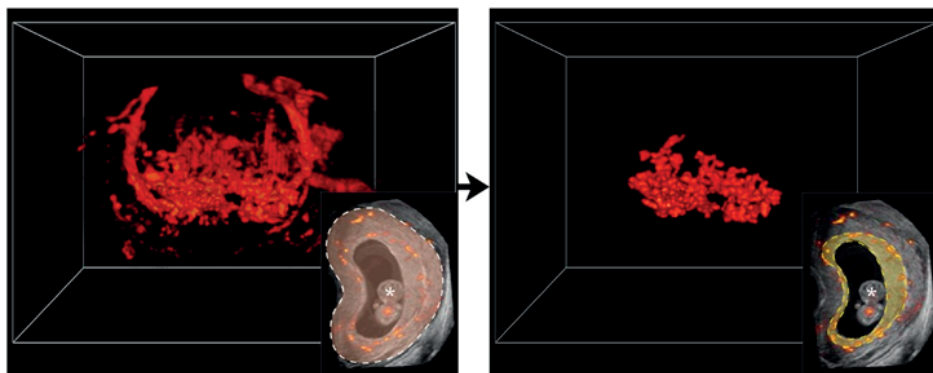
Visualization of a three-dimensional power Doppler utero-placental vascular volume in Virtual Reality. On the left; complete three-dimensional power Doppler vascular volume at 9 weeks of gestation. On the right; Using grey values of the utero-placental tissue, a virtual brush allows to erase vascular voxels up to the myometrial-placental tissue interface margin, leaving uteroplacental vascular volume (uPVV) to be measured by threshold-based segmentation. Lower inserts; two-dimensional power Doppler image with complete vasculature in color delineated by dashed white line (left), placental vascularization delineated by dashed yellow line (right).
